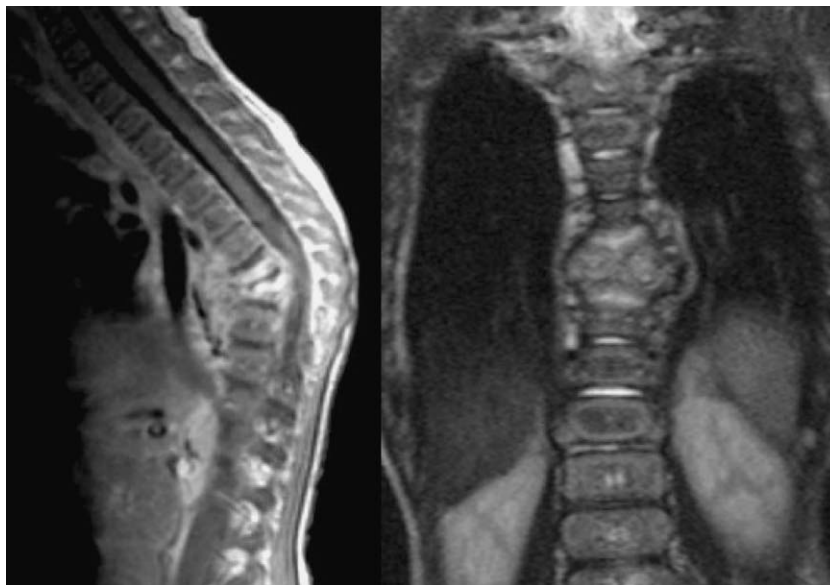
Thoracic (D8–D10) spondylodiscitis: magnetic resonance image at admission.
